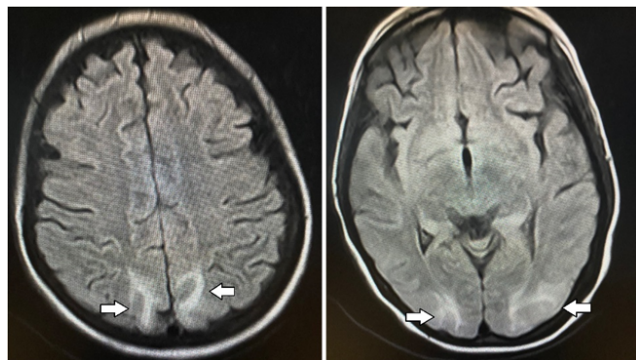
Axial FLAIR image showing hyperintense signal in bilateral parietal and occipital lobes representing vasogenic oedema consistent with Posterior Reversible Encephalopathy Syndrome (PRES)
